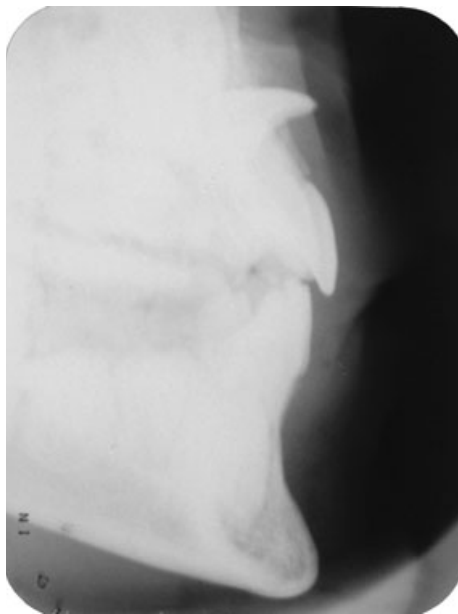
Lateral radiograph showing that the crown of the maxillary right central incisor had turned toward the vestibular aspect near the nasal spine.
